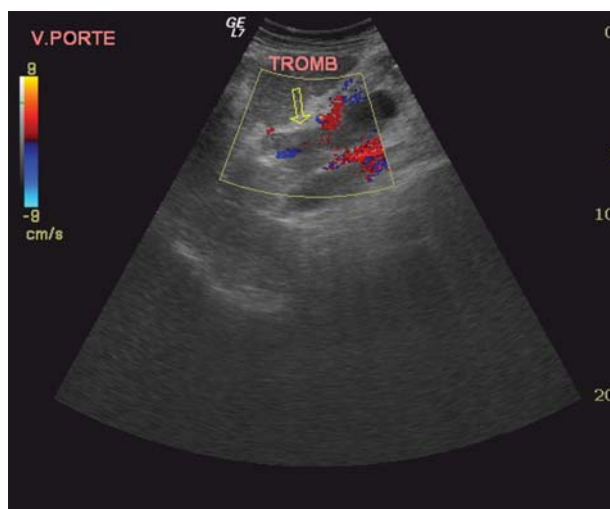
Color Doppler ultrasonography – obstructed lumen by thrombus of dilated portal vein
